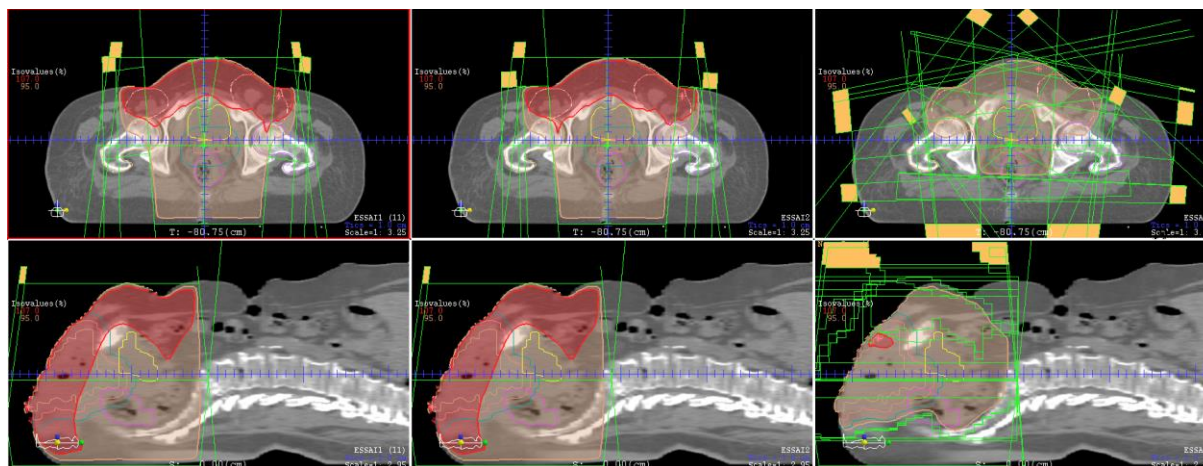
Axial and sagittal reconstruction planning CT slices of SSD (left: a), MSBT (middle: b), and 3D-ACT (right: c) display of the 95% (brown) and 107% (red) isodoses of the prescribed dose
